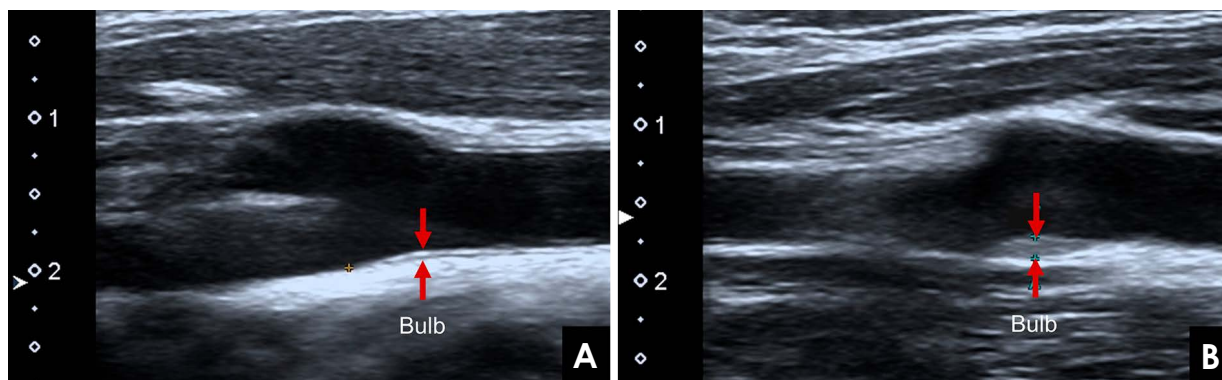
A. Sonographic images depict the normal carotid intima-media thickness of a healthy 31-year-old man. B. The accumulation of plaque at the carotid bifurcation in a matched non-smoker and non-alcohol consumer with high systolic/diastolic blood pressure of 146/100 millimeters of mercury and a pulse rate of 100 beats per minute.
